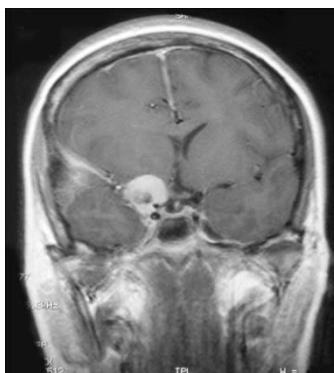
MRI/ T1 with contrast Showing Right sphenoidal Wing strongly enhanced mass
